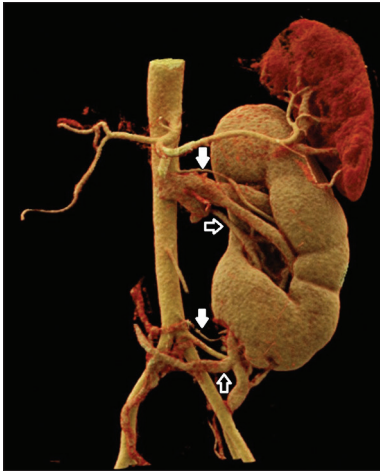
Cinematic volume rendering arterial phase computed tomography of the kidneys showing enlarged solitary left kidney supplied by arteries arising from the aorta at multiple levels (solid arrows) and drained by multiple veins (open arrow). Notice absence of the right kidney and right renal artery. Branches of the superior mesenteric artery are removed for better visualization
